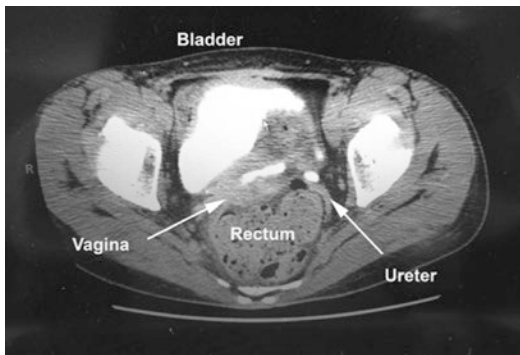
Axial CT image showing contrast extravasation into vaginal cuff in the region of the distal ureter, contrast has also drained into the bladder
